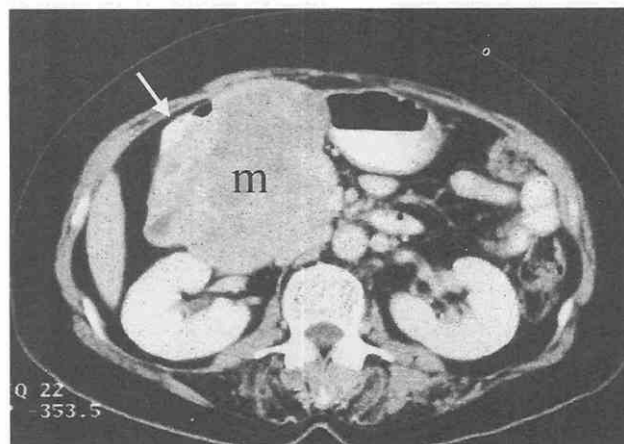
Malignant gastrointestinal stromal tumor. CT scan shows a large, heterogeneous mass (m) growing exophytically from the stomach (arrow).
